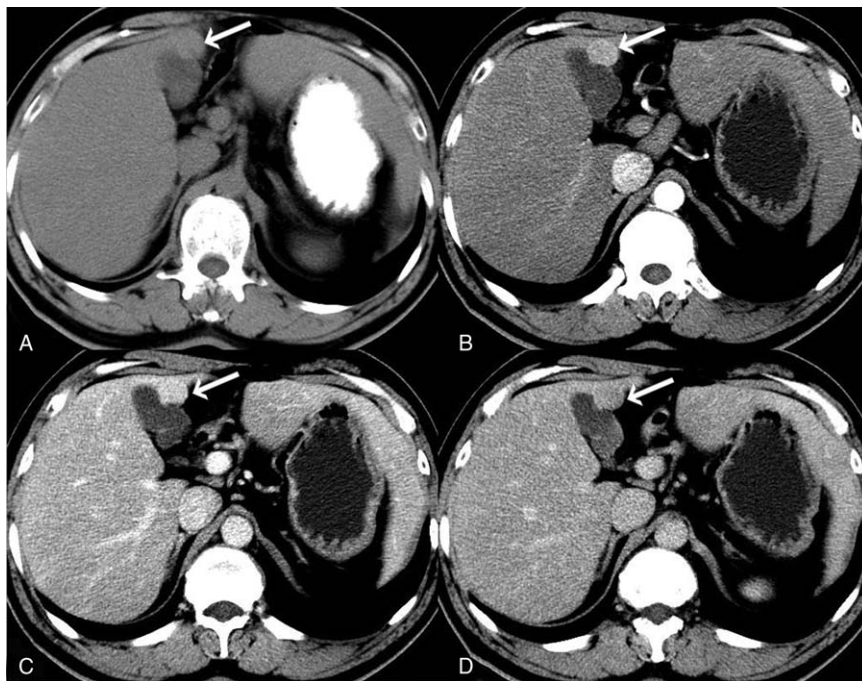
Computed tomography (CT) images of implanted hepatic splenosis. Noncontrast CT revealed a hypodense nodule in SIV of fatty liver (A). A dynamic study showed moderate homogenous enhancement in arterial (B), portal venous phase (C), and hypodensity in equilibrium phase with delayed rim enhancement (D). SIV = segment IV.
